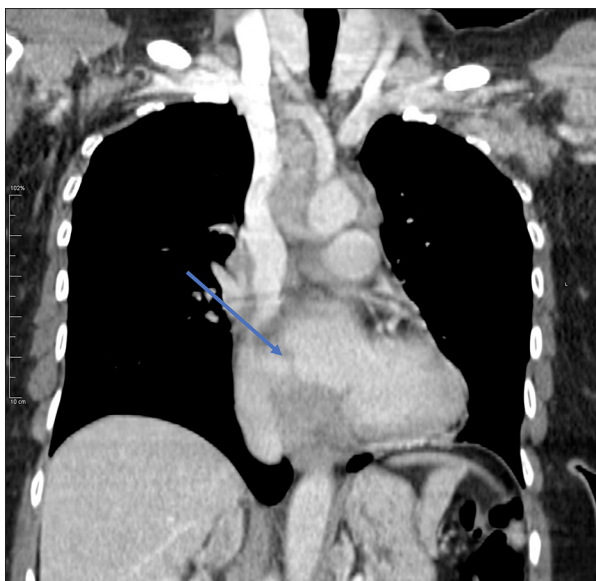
Computed tomography scan showing coronal view of right atrial mass (arrow).
